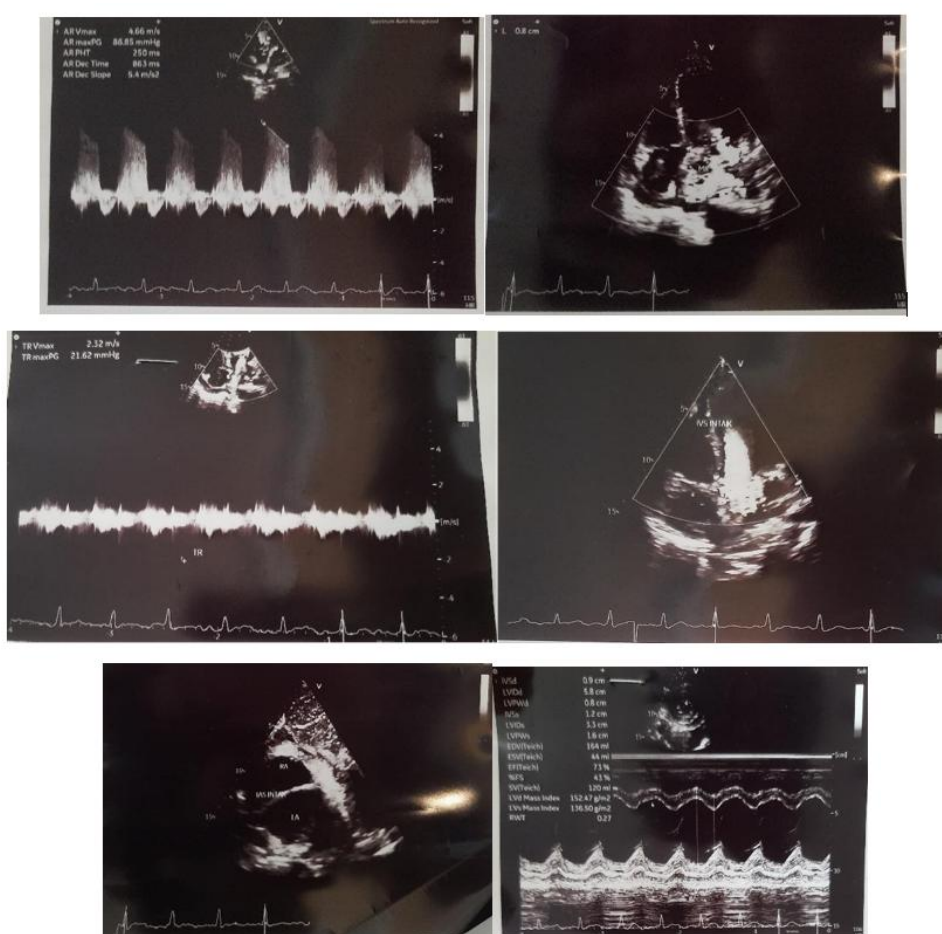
Echocardiography on September 24, 2024
